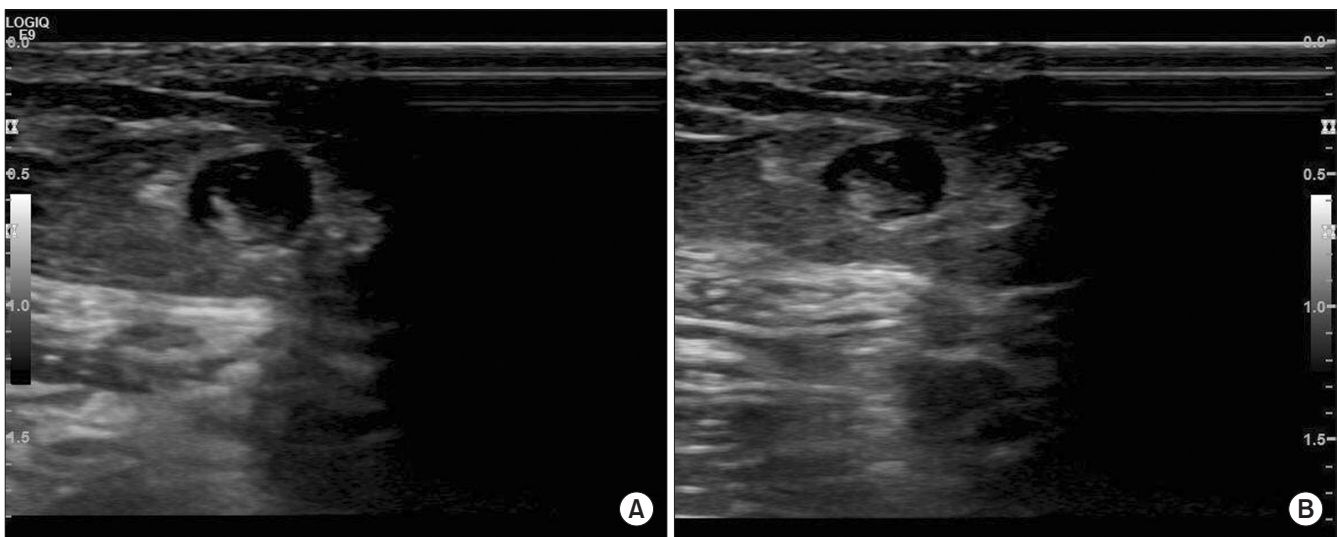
Duplex ultrasonographic images from a 63-year-old woman who underwent hemiarthroplasty for osteoarthritis of the right shoulder. (A) Transverse image shows a thrombus within the right cephalic vein. (B) Transverse image shows that enlarged and tubular structure filled with thrombus is not compressible by the probe.
